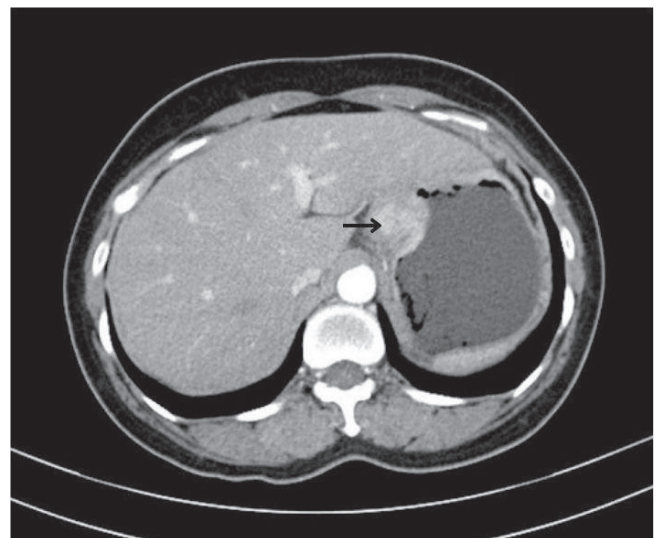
Computed tomography (CT) scan showing asymmetrical thickening of body and antrum of stomach with locoregional lymphadenopathy.
